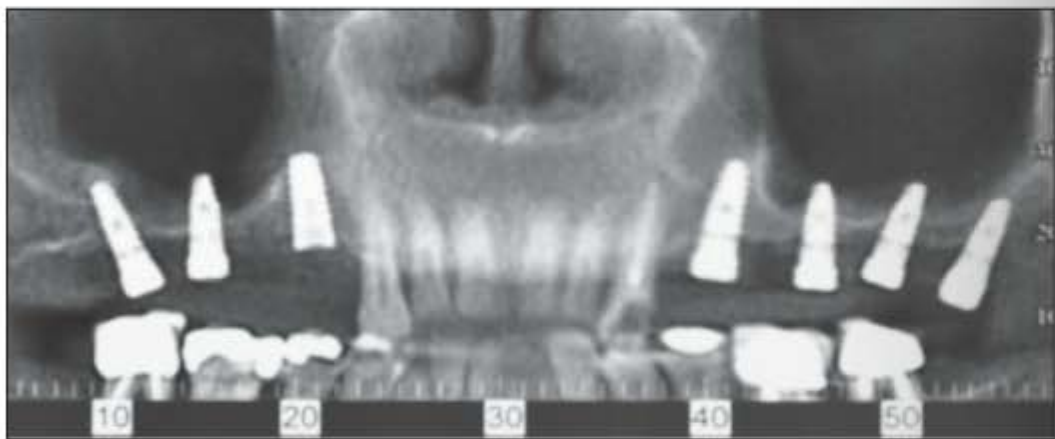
Computed tomography scan of the surgical site 8 months after the procedure.
